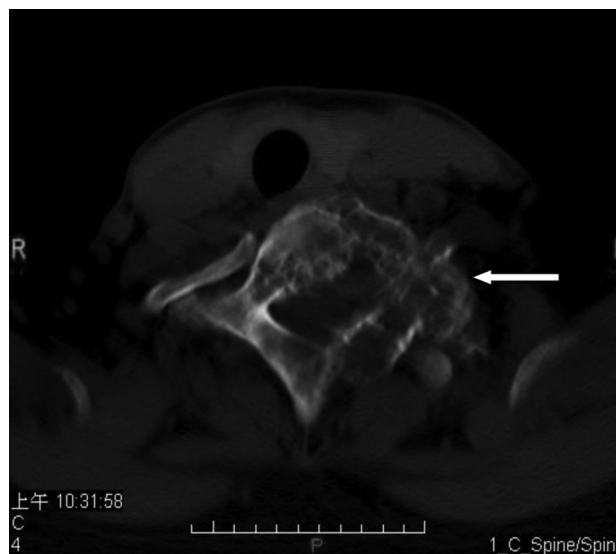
Axial view computed tomography image of the cervical spine in the bone window setting shows an expansile osteolytic lesion (primarily at T1) that involves the left side of the vertebral body, pedicle, lamina, and transverse process. It extends to the left side of the adjacent first rib.
